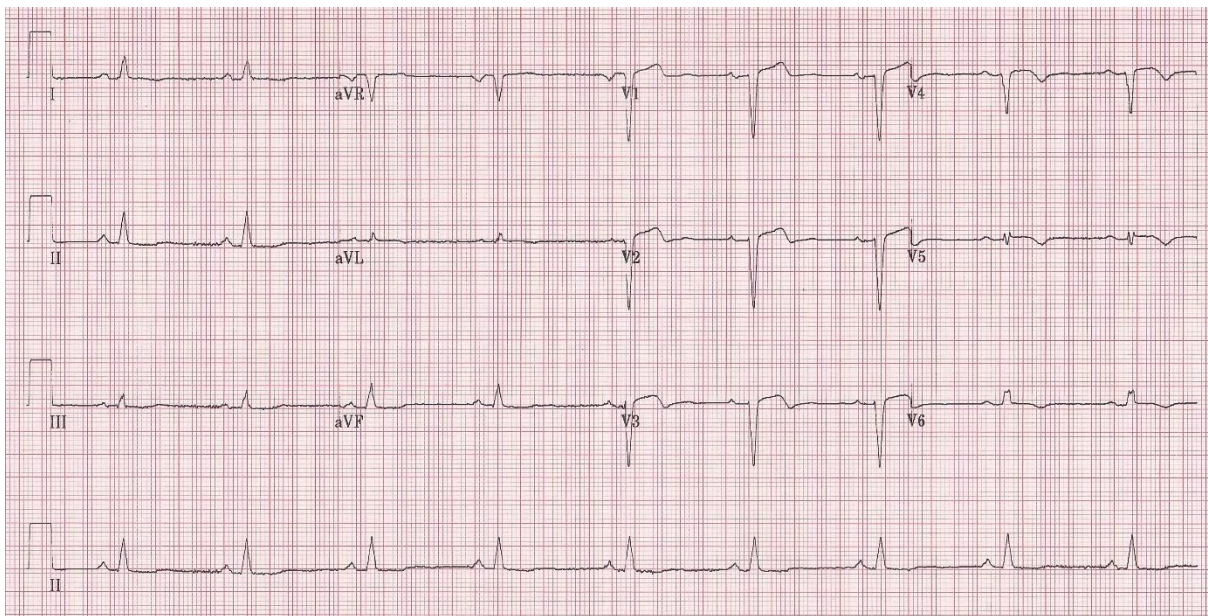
The same patient, 12 months post MI. The ST segments are still slightly elevated. Echocardiography excluded LV aneurysm. Note the Q-waves, loss of R-wave height and inverted T-waves.
